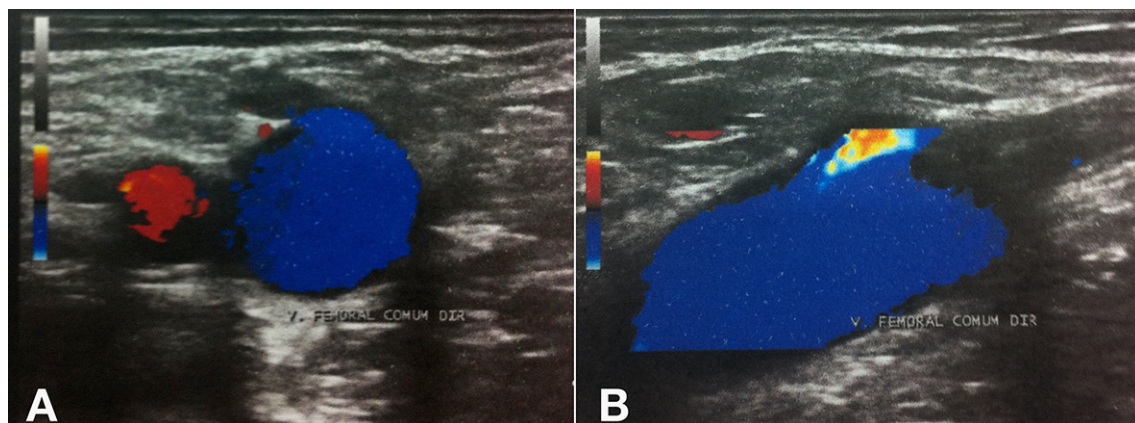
Control Doppler ultrasound after 7 days' treatment with Rivaroxaban. (A) Color-mode image with transverse transducer; (B) Image in color mode with longitudinal transducer.
